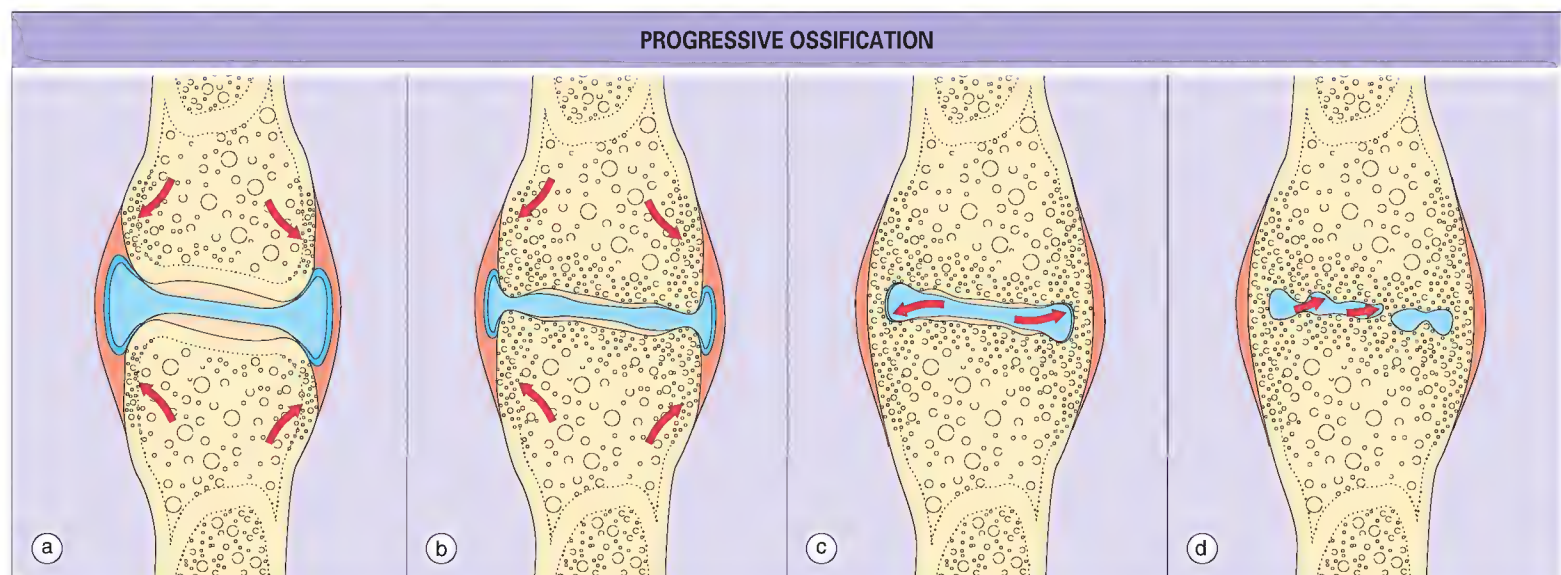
(a) Initially, inflammatory changes are noted at attachments to bone and the adjacent bone marrow as determined by magnetic imaging and scintigraphy. (b) This progresses to bone erosions, at least in the sacroiliac joint in early disease. (c) Capsular ossification leads to peripheral bone ankylosis largely via enthesal calcification. (d) In synovial joints, including the sacroiliac joint and the hip, articular cartilage may be replaced by bony bridges leading to intraarticular ankylosis of bone. The diffuse osteitis that accompanies early enthesitis may result in the joint cartilages' being subject to an immunologic attachment from beneath the growth plate that subsequently culminates in the radiologic appearance in advanced disease.
